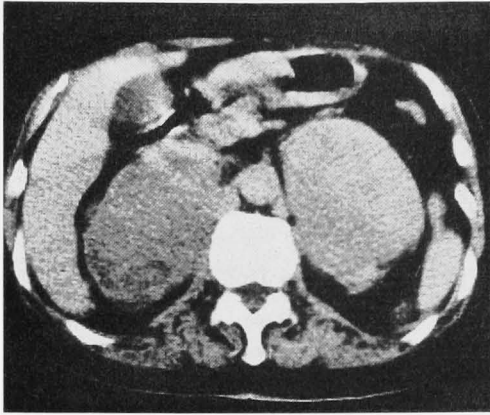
CT-scan shows symmetrical enlarged adrenal masses. The right mass measures  $9.3 \times 5.7$  cm and the left mass  $8.9 \times 6.0$  cm. Additional caudal scans showed no retroperitoneal adenopathies.
